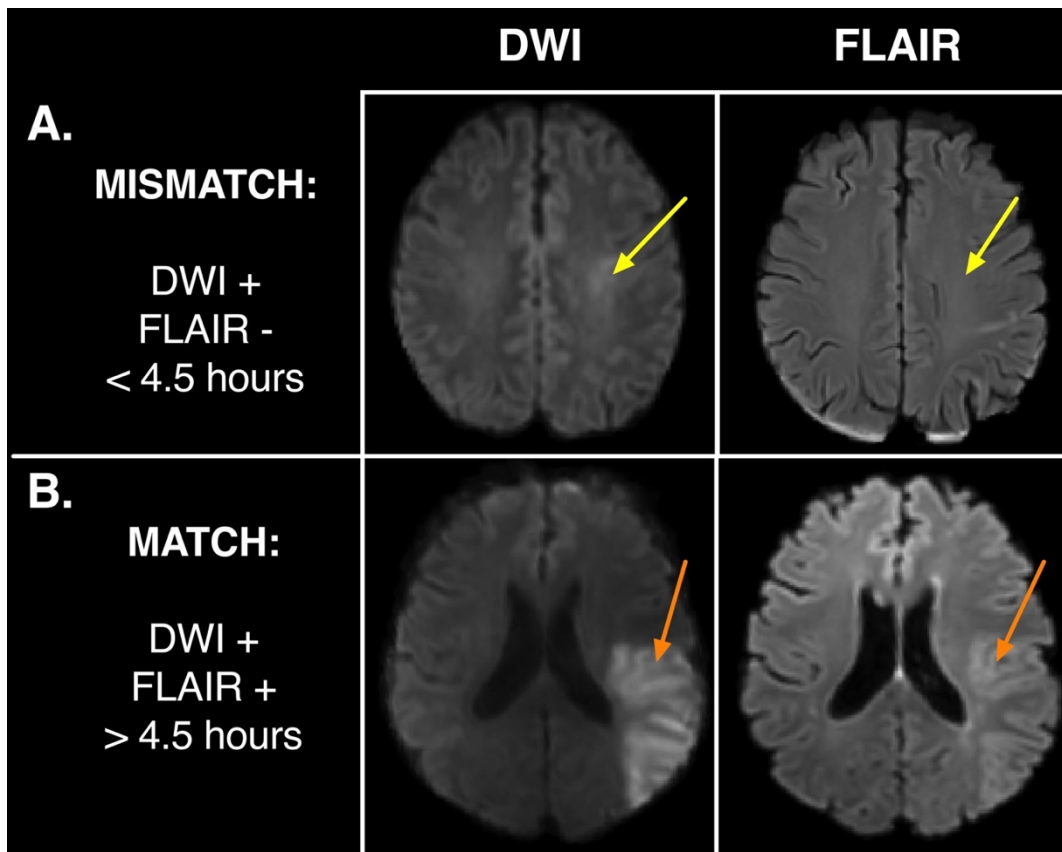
The qualitative, visual based DWI/FLAIR mismatch approach to onset time estimation. A. The patient is classified as within the 4.5 hour treatment window for IV thrombolysis if they show a DWI/FLAIR mismatch, where ischaemic tissue (indicated by yellow arrows) is visible on the diffusion weighted image (DWI +), but is not visible in the same region on the FLAIR image (FLAIR -). B. The patient is classified as beyond the 4.5 hour treatment window for IV thrombolysis if they show a DWI/FLAIR match (where ischaemic tissue (indicated by orange arrows) is visible on DWI (DWI +) and FLAIR (FLAIR +)).
